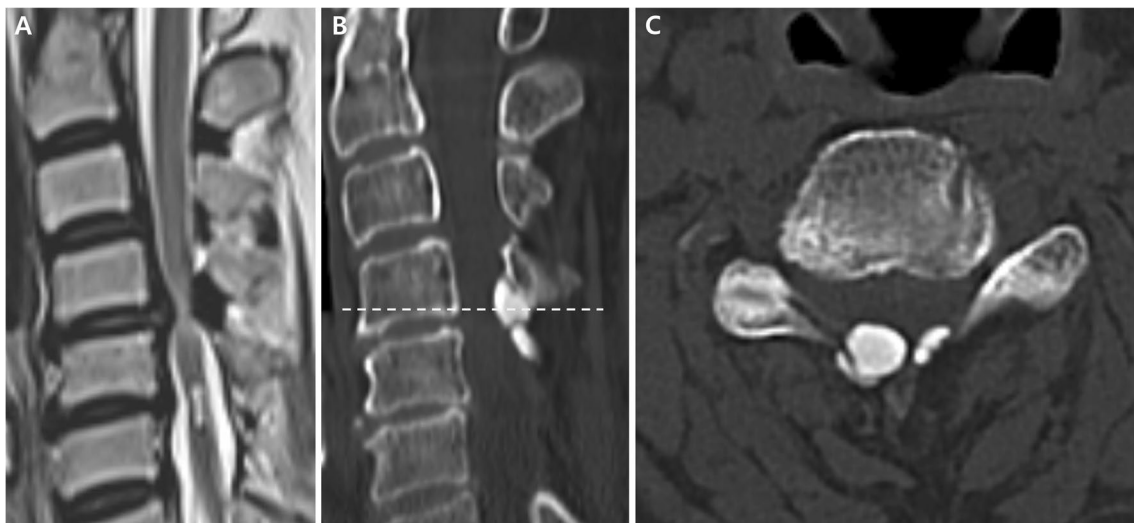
Pre-operative images of Case 2. A: Sagittal plane of MRI scan, displaying the posterior mass at C4-5 with clear cord signal change. B: Sagittal plane of CT scan, revealing the previously operated area at
